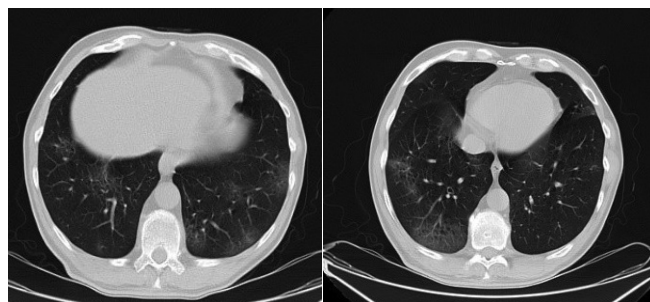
At diagnosis, computed tomography scans show bilateral peripheral ground-glass opacities in the lower lobes (arrows)
